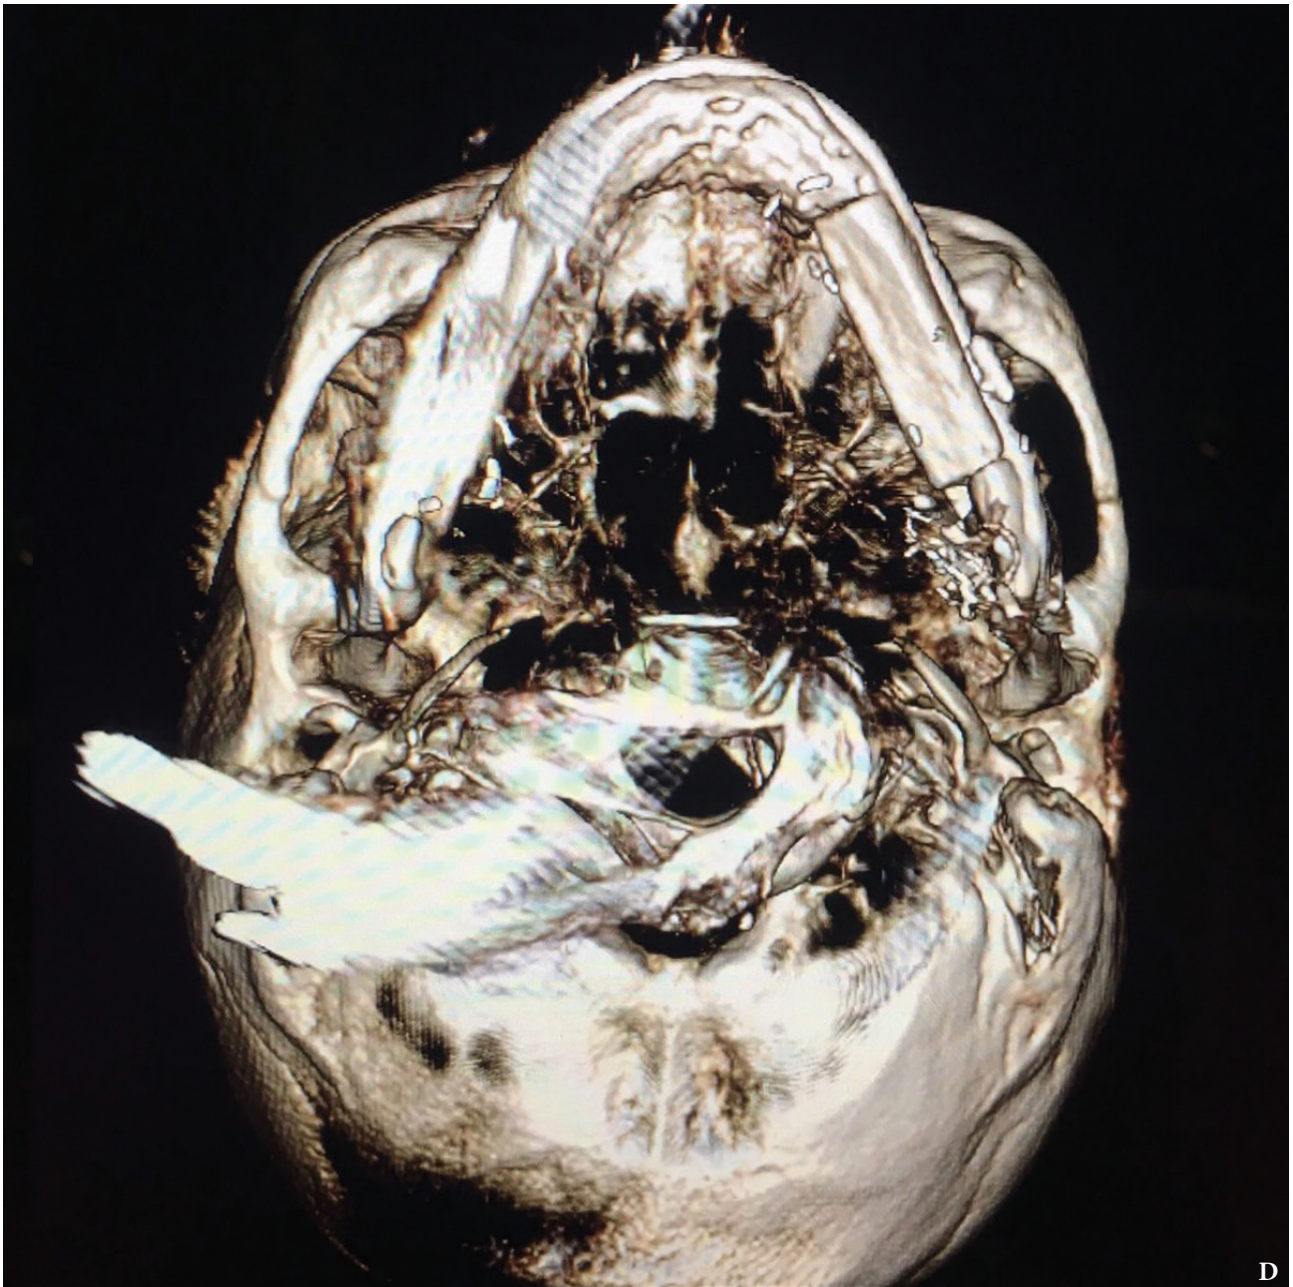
(cont'd). Postoperative control of reconstruction with 3D-CT: Axial view (D).
